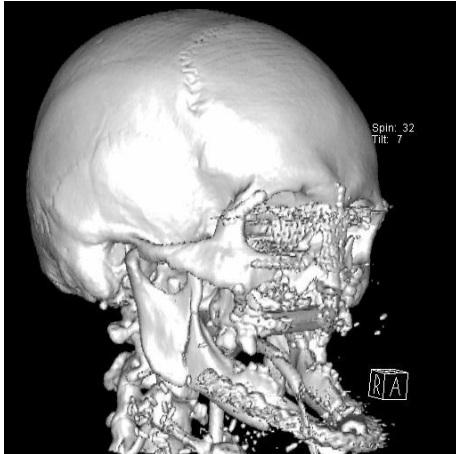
3D CT reconstruction of the skull and viscerocranium (post-surgery), right-anterior view. A 38-year-old patient attempted suicide with a rifle, resulting in defect of anterior mandibular arch, hard palate, anterior maxilla, and nose. Reconstruction involved a fibula free flap (FFF) for the mandible and floor of the mouth, a radial free forearm flap (RFFF) for upper lip and the maxilla, and in another surgery scapula osseous free flap (SOFF) for the hard palate. Additional reconstructions included local flaps for the lower lip and neck defect, a reverse Karapandzic flap for the upper lip, and a rib graft and frontal forehead flap (FHF) for the nose.
